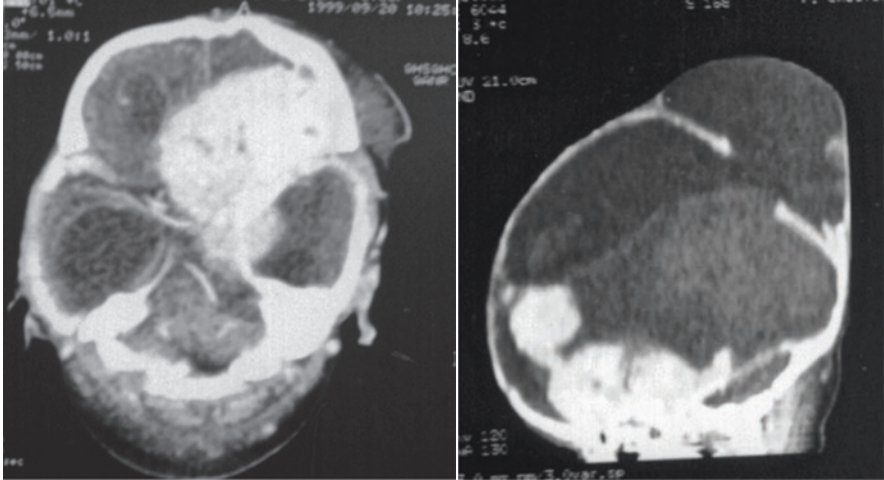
CT scan: immature teratoma, neonate male with a brain tumor and encephalocele ruptured at time of delivery
